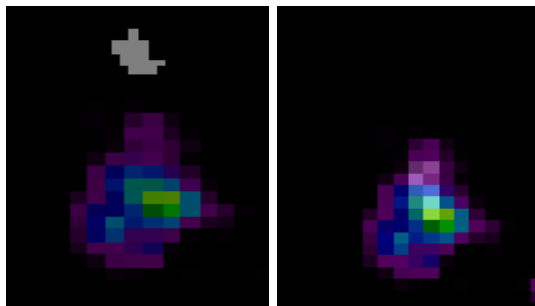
Cross-section of vessels segmented from MR (white) and Doppler US (color) before (distance=11.36mm) and after (distance=1.41mm) registration.
